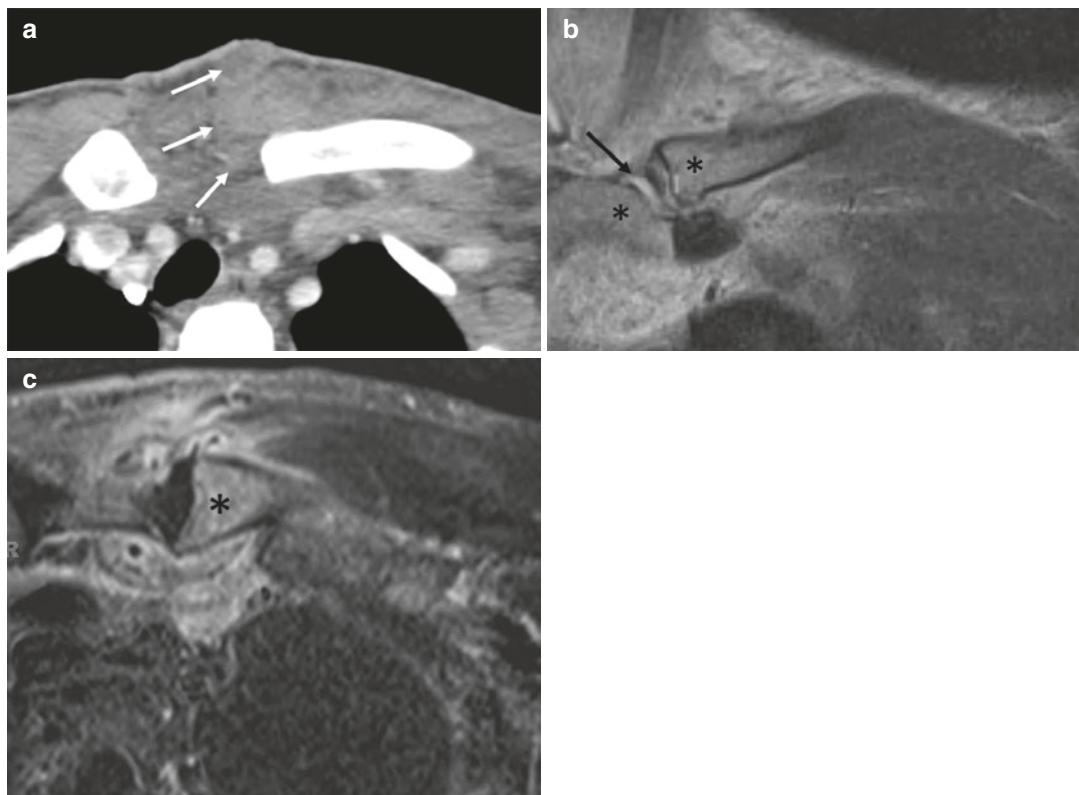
Twenty-seven-year-old man who presented to the emergency department with acute left chest wall pain and swelling. Radiographs of the shoulder and chest were normal (not shown). (a) Transverse post-contrast CT image of the chest wall shows skin thickening, small subcutaneous abscess, and inflammation extending to the left sternoclavicular joint (white arrows). Coronal STIR (b) and transverse T1-weighted fat-suppressed post-contrast
